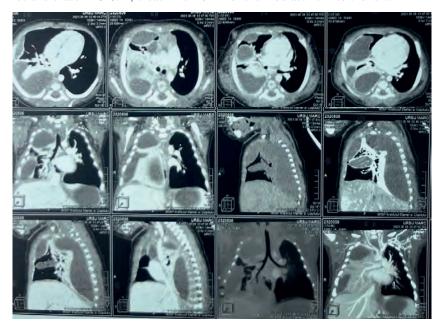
Child U.M., aged 36 days. Computed tomography performed preoperatively on the 9th day after the onset of the disease (explanations in the text)
